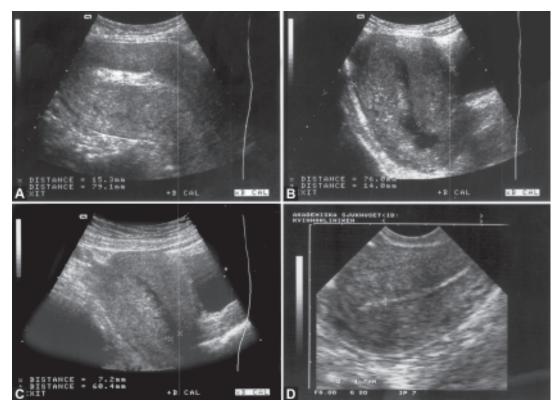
to C: Transabdominal ultrasound scans of a normal puerperal uterus on day 1. (A) Longitudinal scan; (B) Coronal scan; (C) Transverse scan
